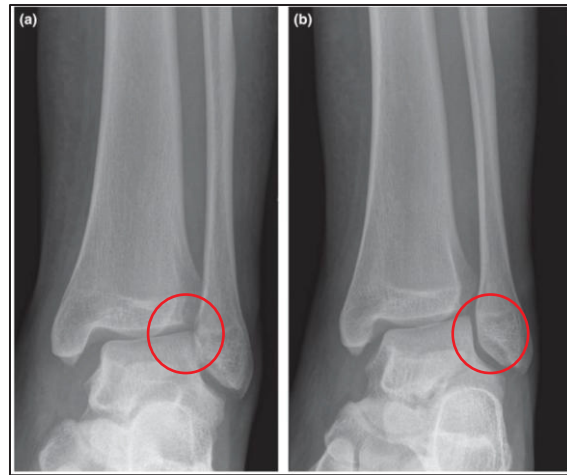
Ankle radiographs, AP (a) and Mortis (b) view demonstrating the syndesmosis widening and widening of medial clear space in red circles
